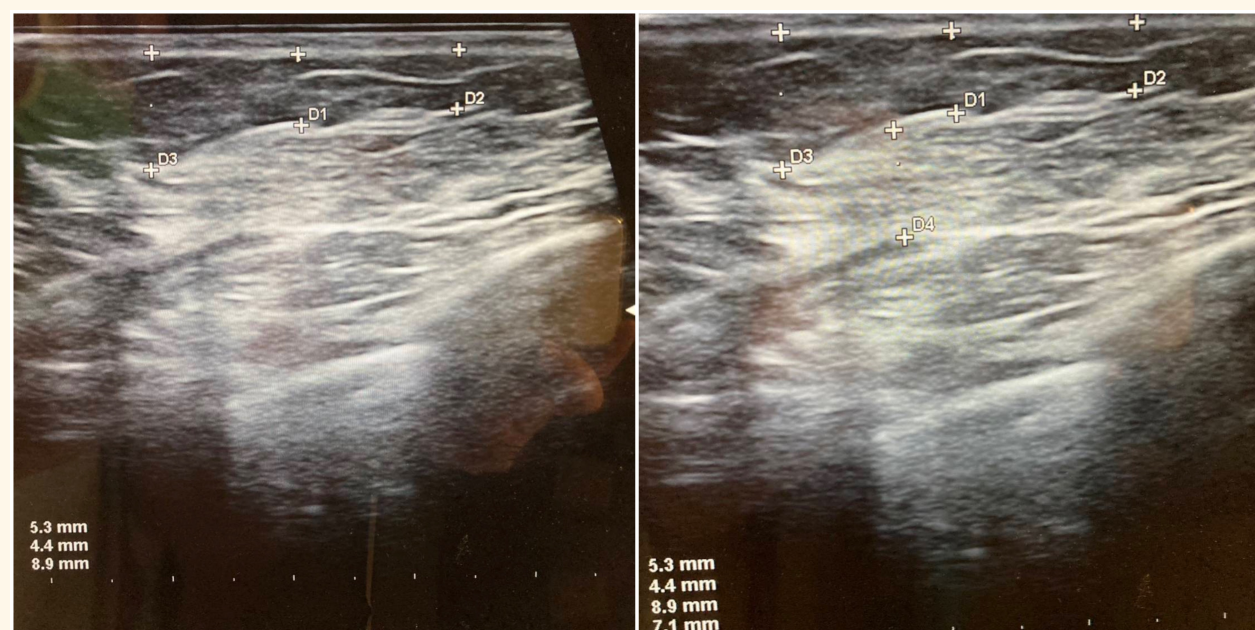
Sonography revealed thicker subcutaneous tissue layer and spasm of pectoralis muscle layer.
